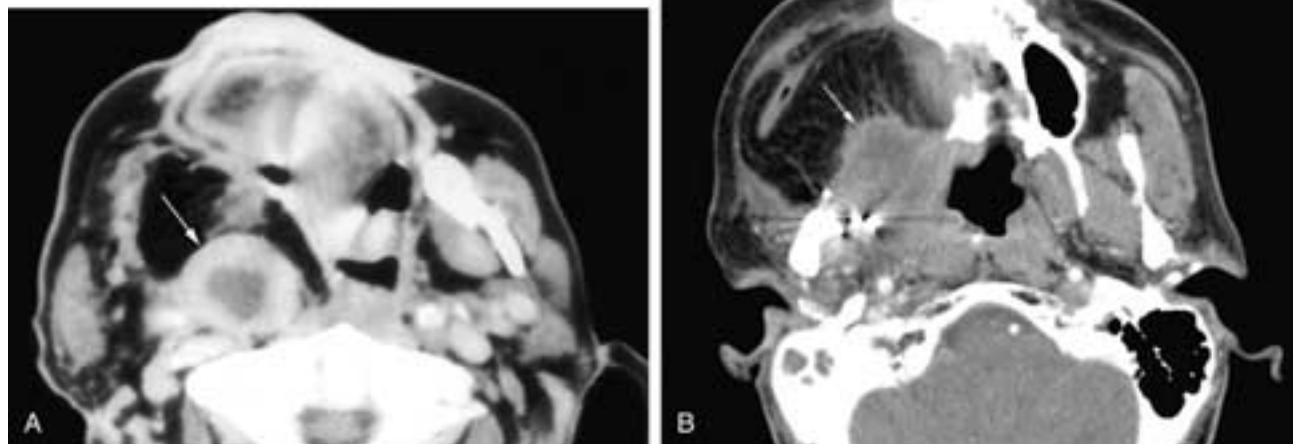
Axial contrast-enhanced CT scan (A) on a patient who has had a right mandibulectomy and right pharyngectomy with a right neck dissection. There is a nodule of recurrent squamous cell carcinoma within the flap (*arrow*). This was not identified clinically due to its deep location within the flap. Contrast-enhanced CT scan (B) on a patient with a mass similar to that in A. There is a clinically undetected recurrence (*arrow*) deep within the flap.
